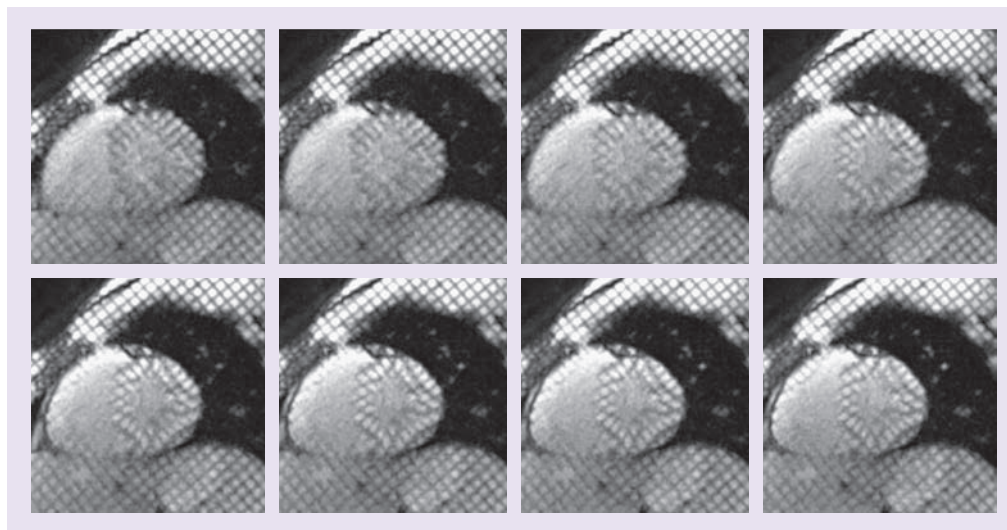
Real-time MRI of the human heart (short-axis view) visualizing strain within the myocardial wall by tagging. Consecutive frames (top left to bottom right) from a respective movie at 34 ms temporal resolution (30 fps) acquired using radial fast low-angle shot (15 spokes, repetition time/echo time = 2.28/1.46 ms, flip angle 8°, $1.5 \times 1.5 \times 6.0$ mm³) with additional tagging (2D spatial presaturation of the magnetization at 8 mm distances) every 2 s. The images represent a 239-ms period of a single cardiac cycle demonstrating the distortion of the applied rectangular saturation pattern in the myocardial wall (top left) due to subsequent systolic contraction and wall thickening (lower row).
